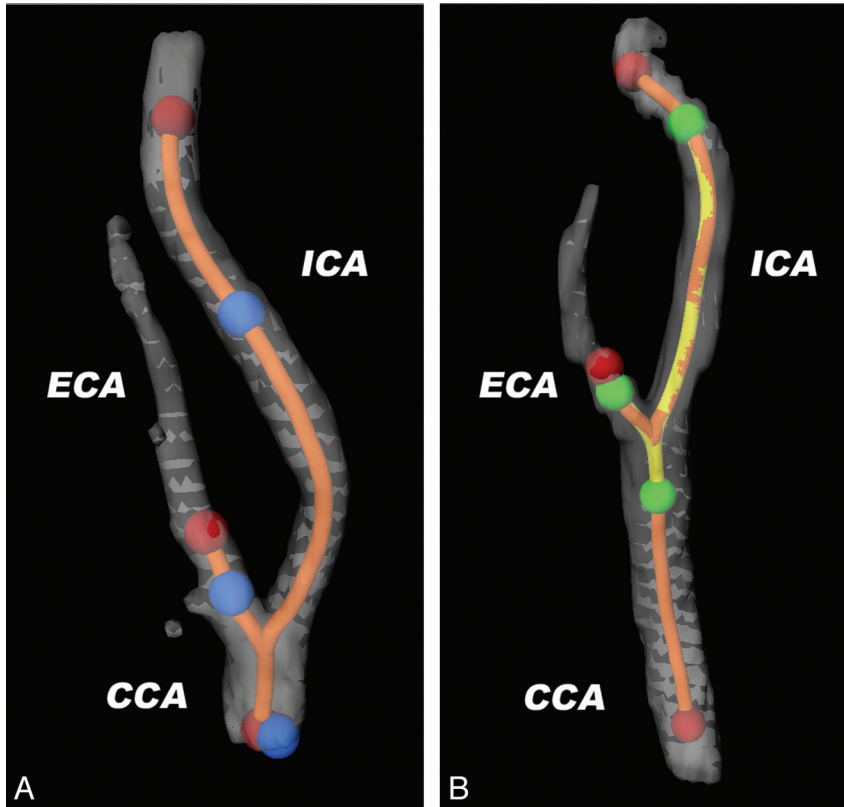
Explanation of the method of semiautomated registration of vessel wall range of interest. 3D reconstructions of the lumen segmentations of a carotid bifurcation at FU (A) and at BL (B). Lumen segmentation is semiautomatically generated after clicking 3 initialization points in the CCA, the ICA, and the ECA, respectively (red dots), separately in both FU and BL datasets. From this lumen segmentation, CLLs are extracted (orange line). On the FU CTA, the vessel range containing atherosclerotic plaque is defined by clicking another set of initialization points (blue dots). The absolute distances along the CLL between the 3 blue points are measured and copied to the CLL of the BL CTA (yellow line), which define the range on axial images to be analyzed by the automated plaque segmentation tool (green dots).
